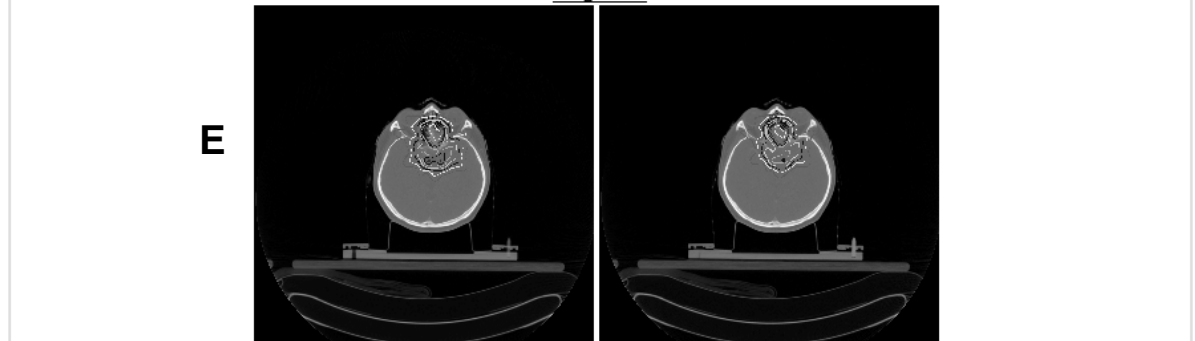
Screenshot Showing an Overview of a Treatment Plan. A: Tabs that Display Different Page Views. TP Overview - Shows the General Overview showing the DVH curves and the DICOM CT Images with Isodose Curves Overlaid. TP Evaluation Page - Shows Quantified Knowledge. TP Knowledge Base Search Page - Allows Users to Query for Specific Knowledge. TP Comparison Page - Shows Quantified Knowledge for Two Different Treatment Plan iterations in Comparison Mode. B: Timeline Display Showing all Treatment Plans, both Current and Historical of a Particular Patient. C: Drop-Down Window Allowing the User to View Different iterations Within a Current Plan. D: DVH Curve of a Particular Plan with Overdose Region Shaded for the Particular Critical Structure, in this case, the Optic Chiasm. E: DICOM Images with Isodose Curves Overlaid from the TPS. All Data is in DICOM-RT Format
